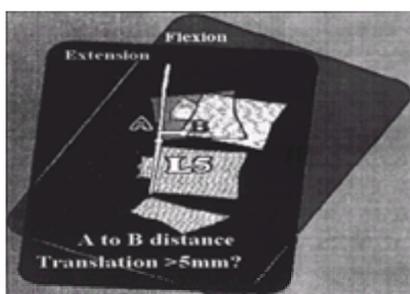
X-ray translation of instability. Superimpose the vertebral image below the slip (here the L-5 image) from the hyperflexion and hyperextension lateral films. The amount of translation can be measured as the distance perpendicular from a vertical line relative to L-5 vertebrae. The distance A to B considering magnification should not normally be more than 5 mm in the lumbar or thoracic spine or greater than 3.5 mm in the cervical spine. (From Bigos SJ. *Housestaff handbook for back problems*. Seattle: SpineMate Publications, 1996.)
